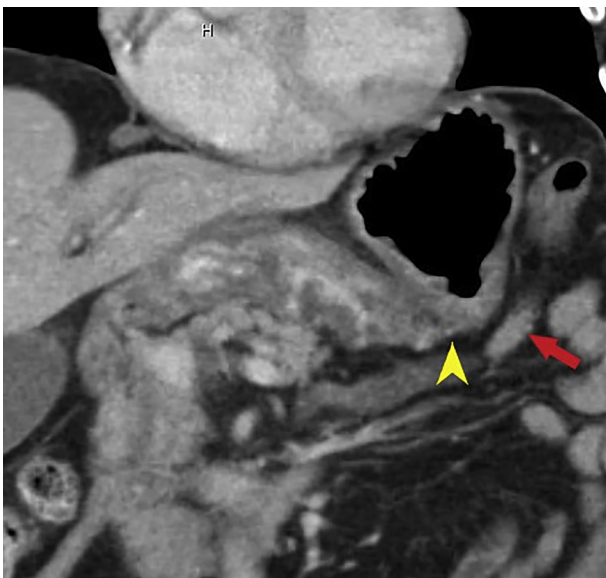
Abdominal CT showing gastric angulation/narrowing (*yellow arrowhead*) and the target jejunal loop (*red arrow*).
